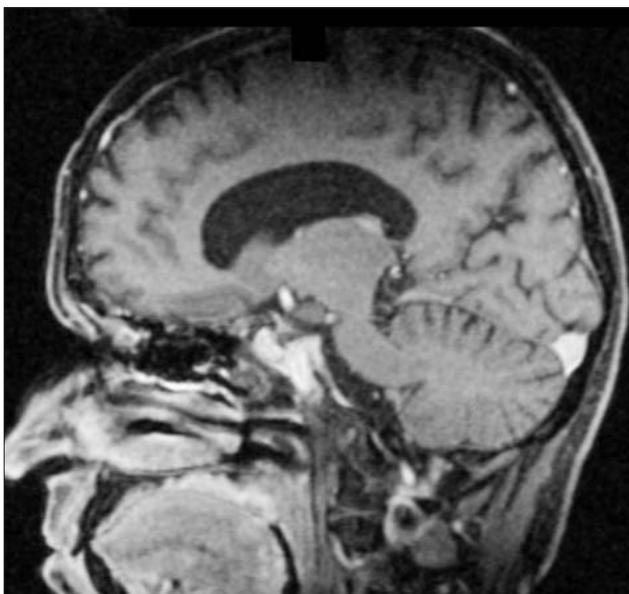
Pituitary Magnetic Resonance Imagery on a 65-year old male diagnosed with Nelson's syndrome (presented scan is from 2015, 28 years after bilateral adrenalectomy)
